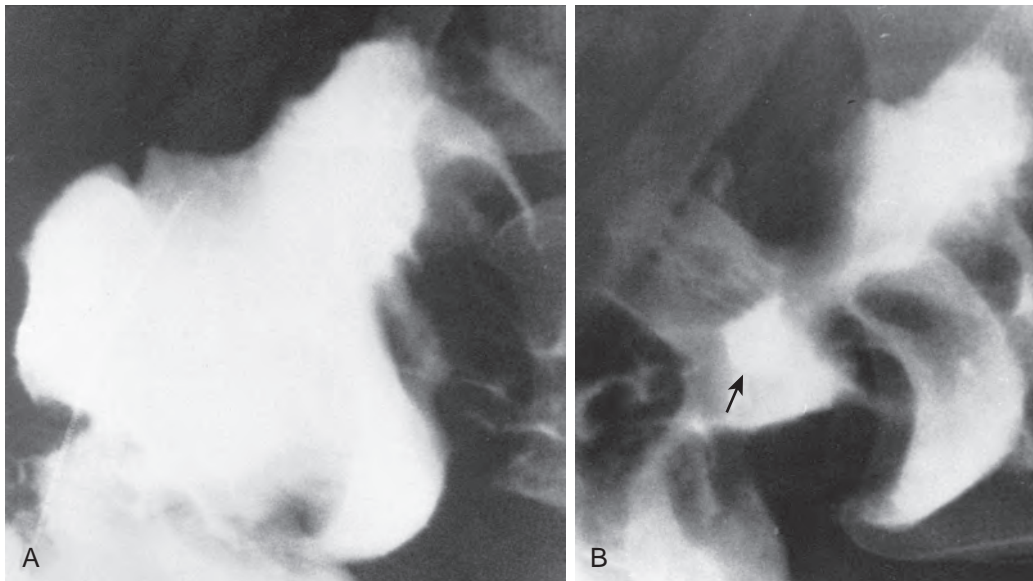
Importance of prone compression for anterior wall duodenal ulcers. A. Initial prone view shows no evidence of a duodenal ulcer. B. Prone compression of the bulb with an inflatable balloon clearly demonstrates an ulcer crater (arrow) on the anterior wall. This ulcer was hidden in the barium pool on the earlier radiograph.
